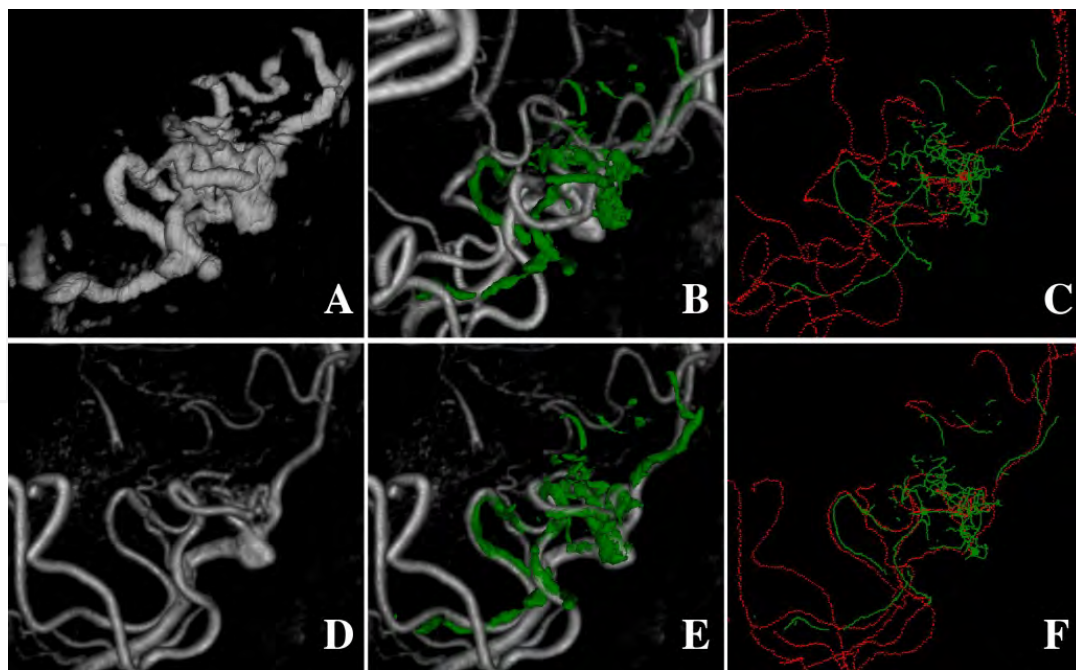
Ultrasound-based shift correction of preoperative MR data during an AVM operation. Top and bottom row shows the situation before and after the MR-to-US registration respectively. A) Ultrasound. D) MR. MR (gray) and US (green) before (B) and after (E) registration. Centerlines from US (green) and MR (red) before (C) and after (F) registration.
